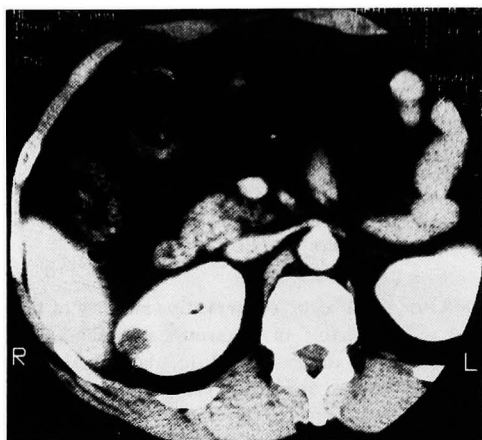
CT scan of the abdomen revealed a right renal mass, 19mm in diameter, with heterogeneous contents.
